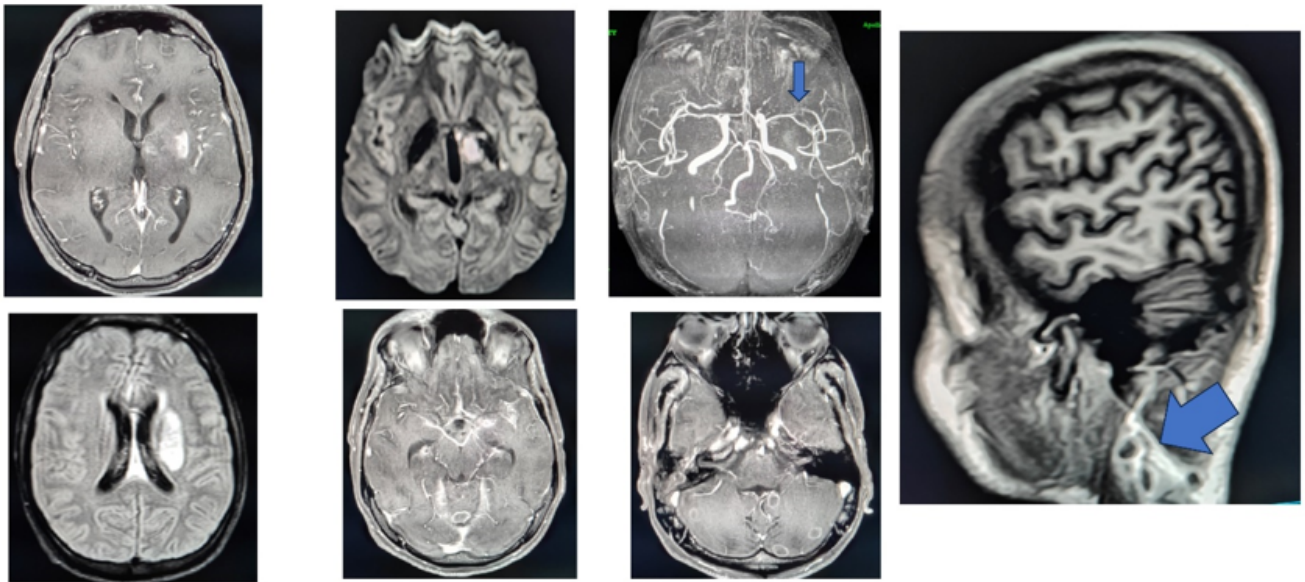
MRI of the brain with contrast revealed acute to subacute infarcts in left para ventricular white matter, centrum semi-ovale, left thalamus, left ganglio-capsular area; multiple ring-enhancing lesions in cerebellar, cerebral hemispheres, along with leptomenigitis. MR Angiogram showed left M2 division of middle cerebral artery occlusion (blue arrow) and cervical lymph nodes (thicker blue arrow)
